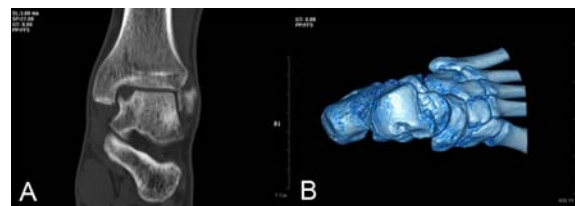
The CT scan of left ankle following the surgery showed the residual bone defect.
